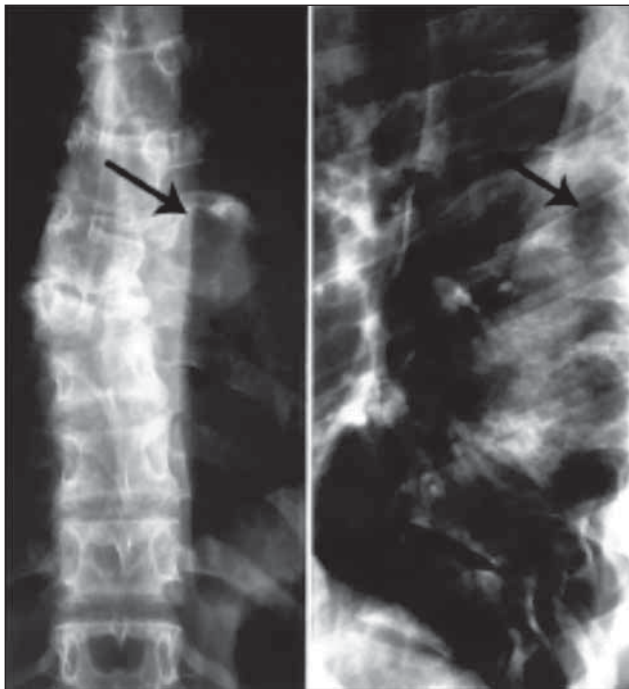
X-ray photography of the thoracic portion of the spinal column dated December 2012. A. Frontal position. B. Lateral position. An abscess with peripheral calcification at the left paravertebral level Th7-Th8 is indicated with arrow.
